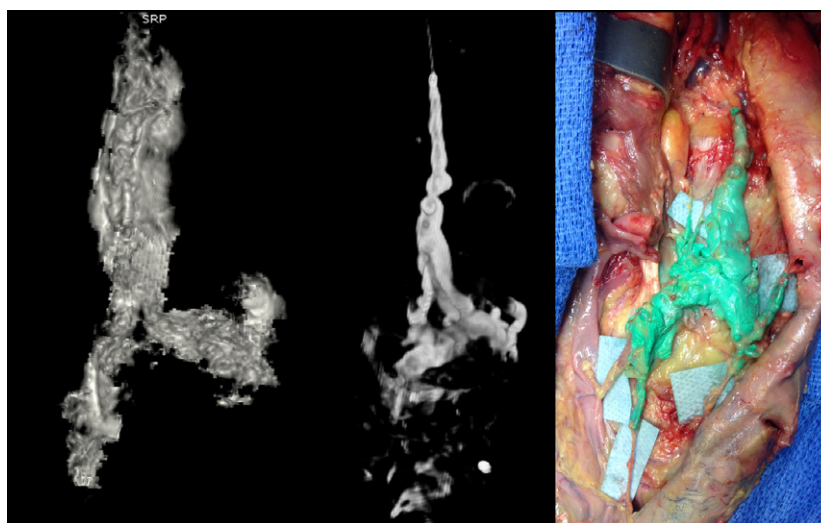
MRI, CT and anatomical (from left to right) results of the cisterna chyli (CC) study in subject number 12. The CC originated from three afferent trunks.
